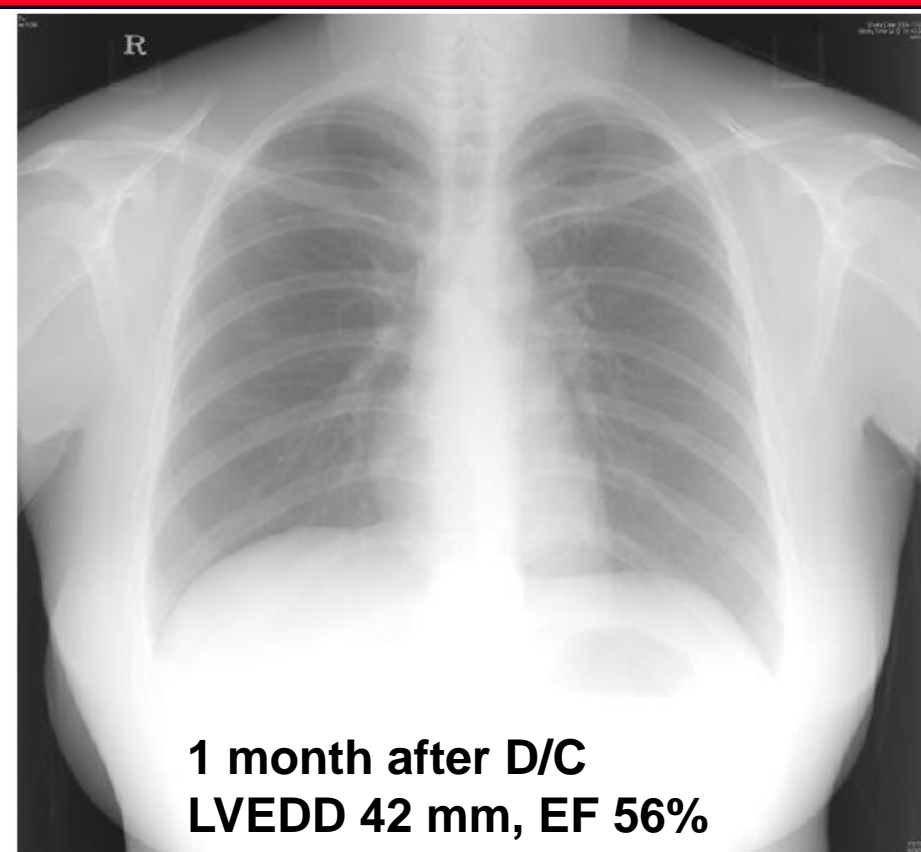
Chest x-ray taken during an outpatient visit (1 month after discharge).
